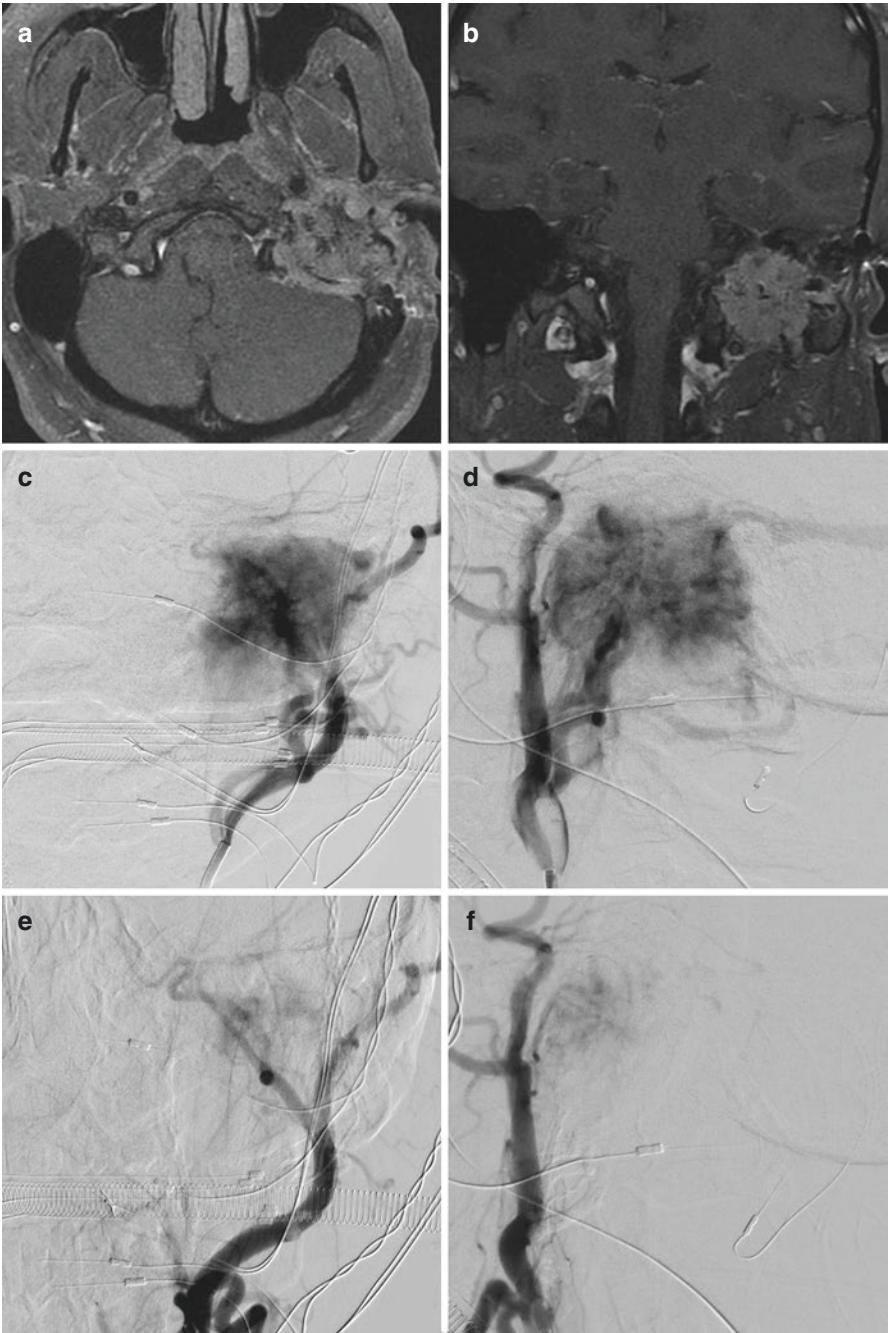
This 15-year-old boy with history of left sided conductive hearing loss and 7th cranial nerve palsy was found to have a left sided glomus jugulotympanicum tumor. MRI of the brain, gadolinium-enhanced T1 fat-saturated sequences in (a) axial and (b) coronal views showing enhancing lesion involving the left jugular bulb, left middle ear cavity with extension into the internal auditory canal and stylomastoid foramen. DSA in (c) frontal and (d) lateral views shows vascular tumor blush with arterial supply via the ascending pharyngeal, posterior auricular and occipital arteries. After embosphere and NBCA embolization, DSA in (e) frontal and (f) lateral views shows markedly reduced tumor blush. Estimated blood loss at surgical resection 24 h after embolization was 800 ml
